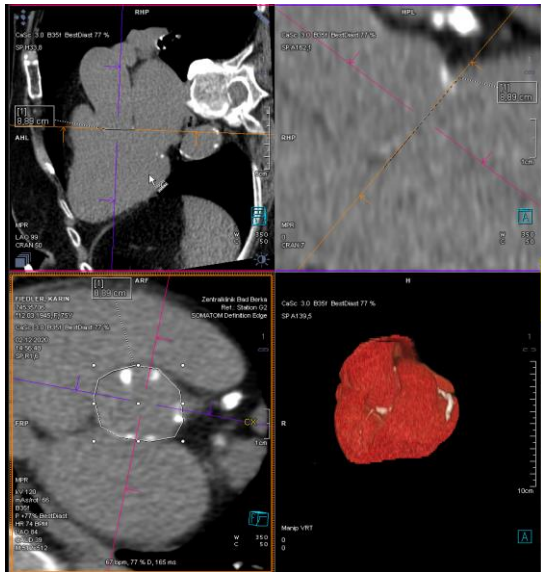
the measurement of annulus area in native CT.
